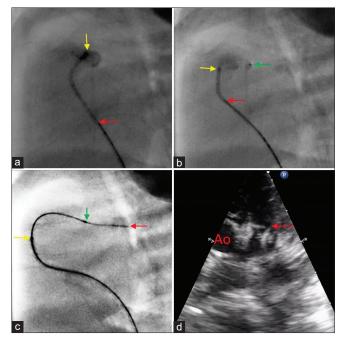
(a) Right ventricular outflow tract angiogram shows a well-formed atretic pulmonary valve with a noncoaxial Judkins right coronary catheter (yellow arrow) lying away from pulmonary valve prohibiting safe movement of Conquest Pro coronary guidewire (red arrow). (b) Coronary microcatheter (green arrow) placed through the catheter bridges the gap between catheter tip and pulmonary valve. Radiopaque marker allowed positioning of microcatheter to the center of atretic pulmonary valve (c) Guidewire (red arrow), placed through microcatheter (yellow arrow), perforating the pulmonary valve. The movement of guidewire and microcatheter has pushed the catheter back in right ventricular outflow tract away from the pulmonary valve. (d) Echocardiogram shows guidewire across pulmonary valve through a central perforation with normal motion of pulmonary valve leaflets
